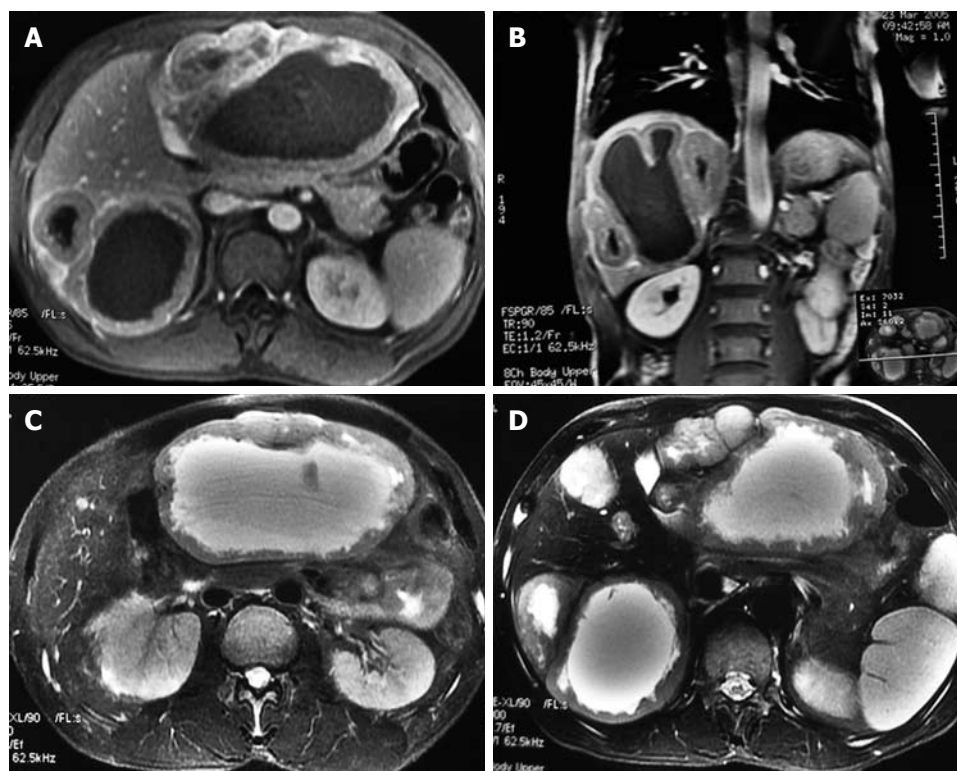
Axial fat-suppressed T2-weighted turbo spin echo magnetic resonance imaging showing two large lesions (A) and several small cyst-like lesions (B) in liver, and coronal and transverse T1-weighted imaging showing thickened wall of lesions with a ragged appearance (C) and enhancement (D) in liver.
